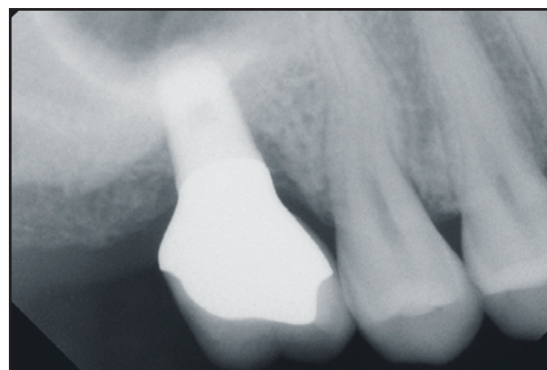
Periapical radiograph of implant-supported restoration at site #3 taken after 1 year in function.
